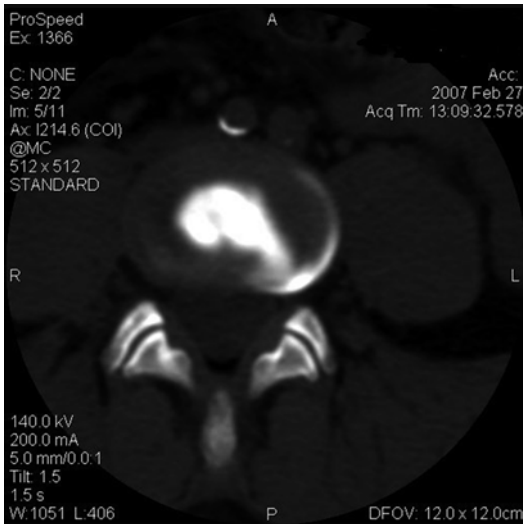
Axial post-diskography CT scan with grade 4 annular tear. Contrast extends into the left posterior quadrant and into a circumferential tear
